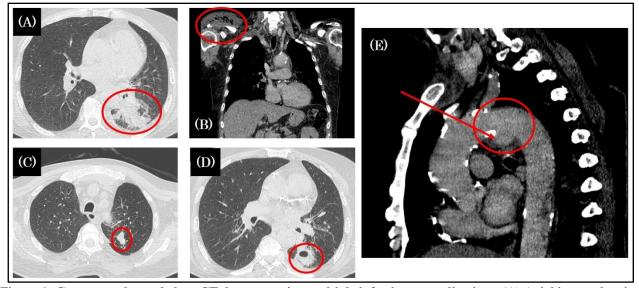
Contrast-enhanced chest CT demonstrating multiple infectious complications. (A) Axial image showing left lower lobe consolidation with cavitation consistent with necrotizing pneumonitis (red circle). (B) Coronal image depicting an emphysematous soft-tissue collection in the right shoulder compatible with an abscess (red circle). (C–D) Axial lung window images revealing cavitary nodules in the upper and lower lobes, suggestive of septic emboli (red circles). (E) Sagittal reconstruction highlighting a saccular aneurysmal dilatation of the aortic arch, diagnostic of a mycotic aneurysm (arrow, red circle)
